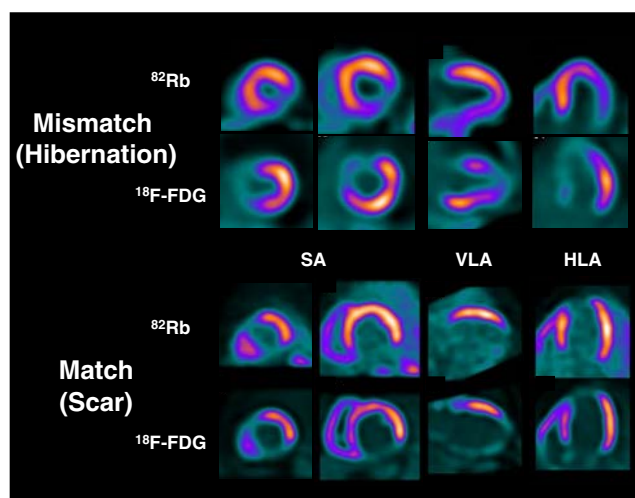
PET patterns of myocardial viability, as determined by measurement of rest perfusion, using ^{82}Rb , and glucose utilisation, using ^{18}F -FDG. A mismatch with reduced perfusion and preserved/increased ^{18}F -FDG uptake in inferolateral wall, indicating hibernating myocardium, is shown on top. Note that ^{18}F -FDG uptake in ischaemically compromised myocardium can be higher than that of normally perfused myocardium, emphasising the need for combined assessment of perfusion and metabolism to avoid misinterpretation of metabolic images. Bottom shows a matched perfusion/metabolism defect in inferior wall, consistent with scar. SA Short axis, VLA vertical long axis, HLA horizontal long axis
